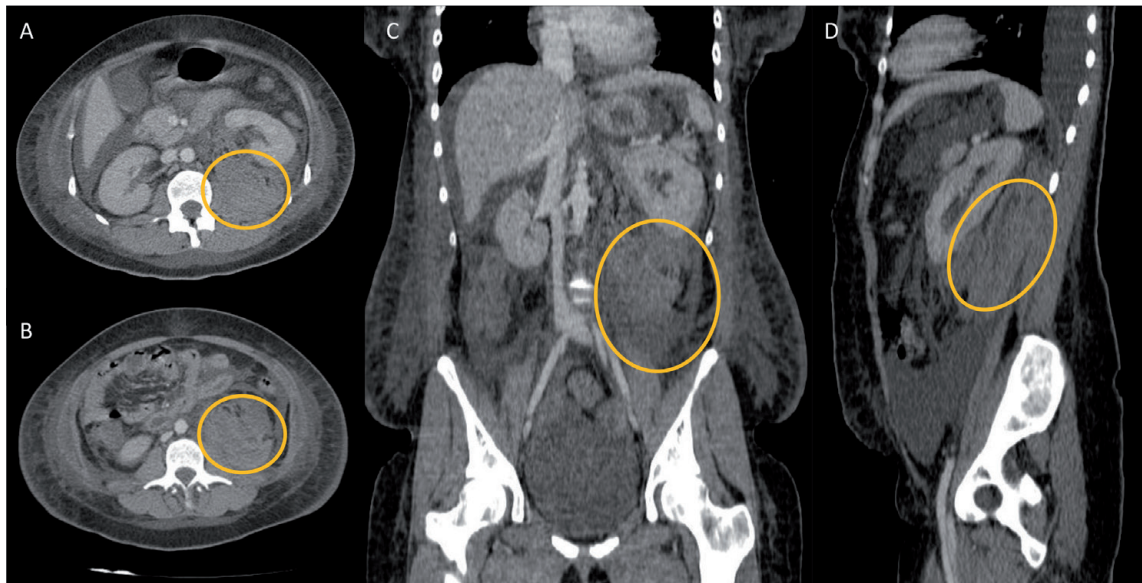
Perirenal hematoma, an hour after percutaneous native kidney biopsy. Computed tomography (CT) scan slices of the abdomen revealed voluminous perirenal hematoma (yellow circle), on the left side. (A and B) Axial scan slices. (C) Coronal scan slice. (D) Coronal scan slice.
